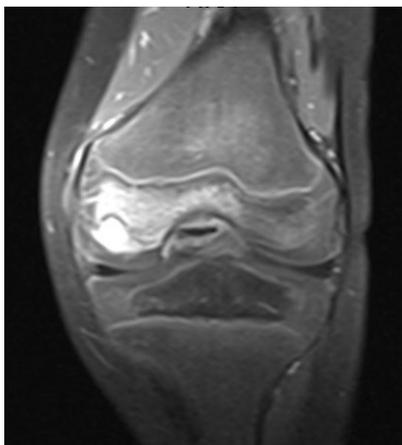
MRI coronal view of left knee
